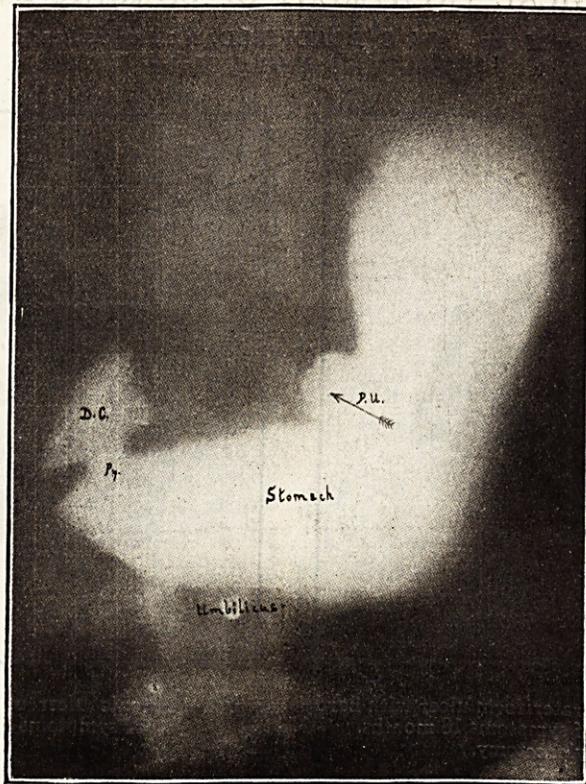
Examination $\frac{1}{2}$ hour after Bismuth meal. Radiograph shows a penetrating ulcer on the lesser curvature.
